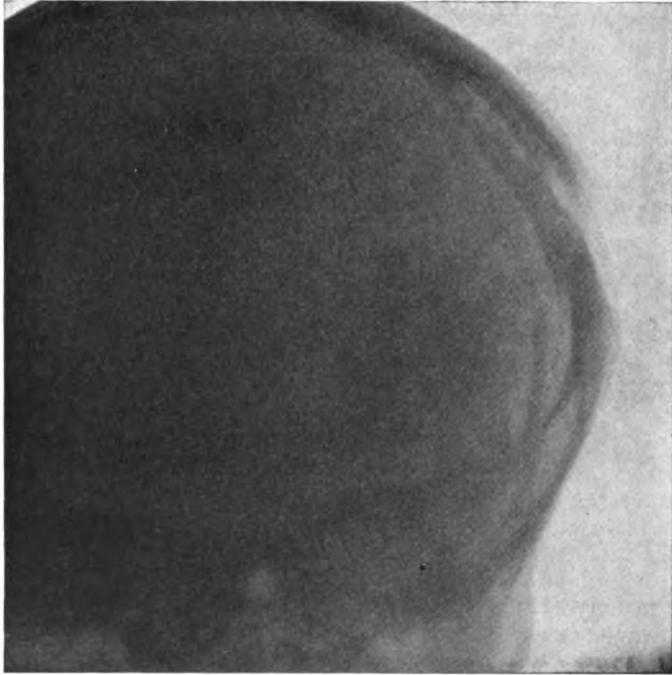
Marginal radiograph of depressed fracture of the skull, seven years after injury.
